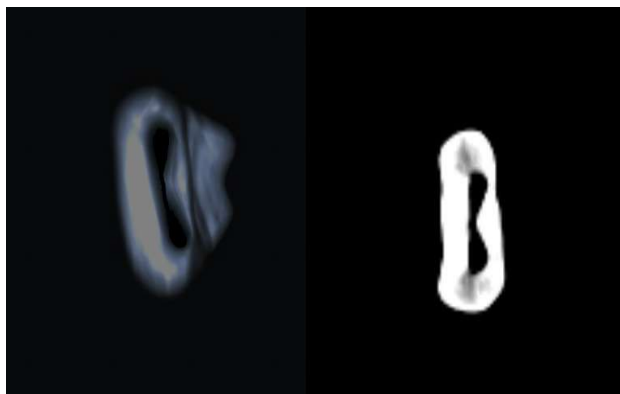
A CBCT image of a lower molar mesial root shows the isthmus between the mesiolingual and mesiobuccal canals.
